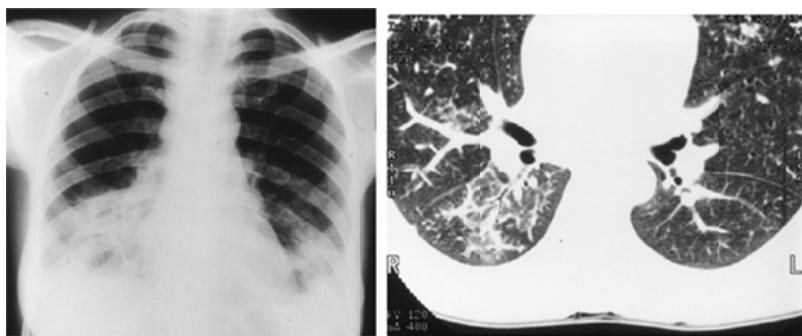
A, Chest radiograph in a patient with acute lupus pneumonitis. B, CT scan in this patient shows right-sided interstitial shadowing.
